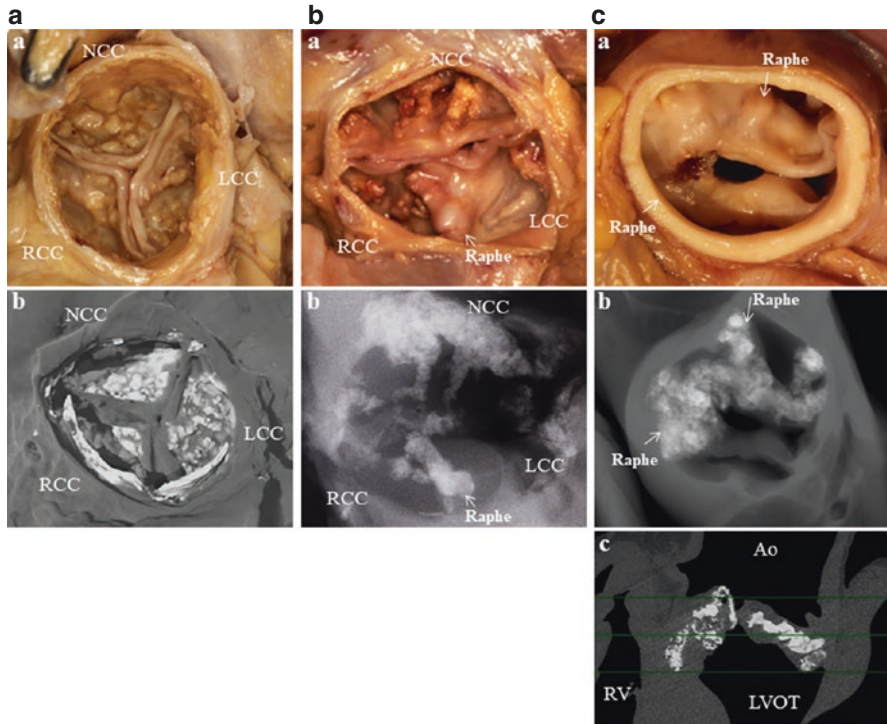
Images of calcified stenotic aortic valve (aortic view): tricuspid, bicuspid and unicuspid. (a) Stenotic tricuspid aortic valve (gross [a] and micro CT [b] images). (b) Stenotic congenital bicuspid aortic valve (gross [a] and X-ray [b] images). RCC and LCC are forming a conjoint leaflet. (c) Stenotic congenital unicuspid aortic valve, a unicommisural valve with slit-like opening that reaches the aortic wall with a single intact commissure (gross [a] and micro CT [b]; transverse, and [c] sagittal views). Abbreviations: CT, computed tomography; NCC, non-coronary cusp; LCC, left coronary cusp; RCC right coronary cusp
